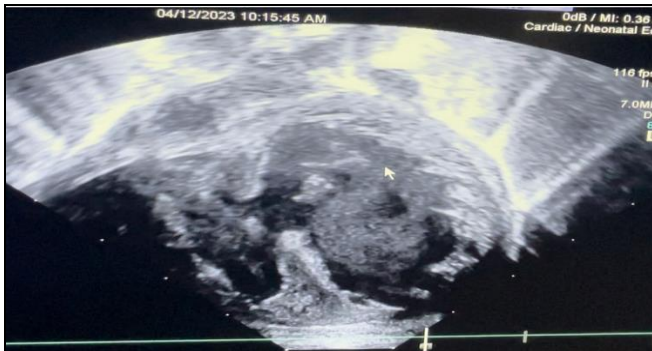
Echocardiography showing large midmuscular VSD
